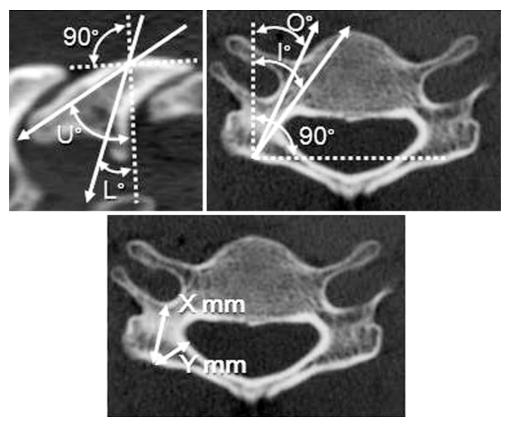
Measurement of insertion directions of short monocortical screws (SMS) on computed tomography images. U, upper angle; L, lower angle; I, inner angle; O, outer angle; X, shortest distance between SMS insertion point and foramen transversarium; Y, shortest distance between SMS insertion point and spinal canal.
